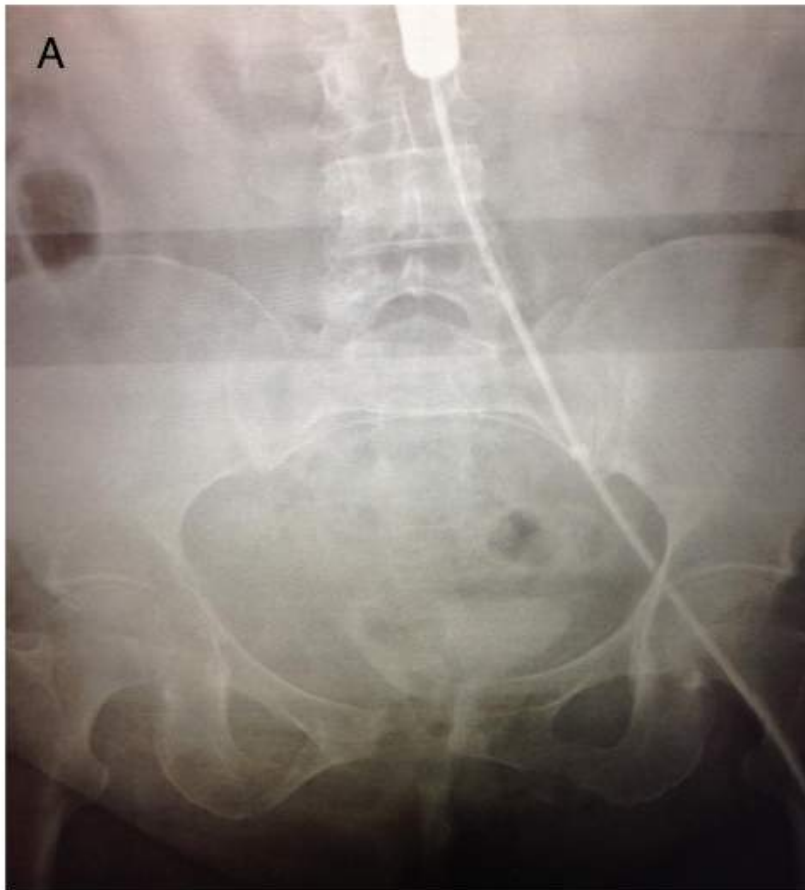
(A) Plain x-ray in ED demonstrating REBOA balloon inflated in REBOA Zone III. (B) Patient with pelvic binding device secured and REBOA catheter in place in left common femoral artery.
